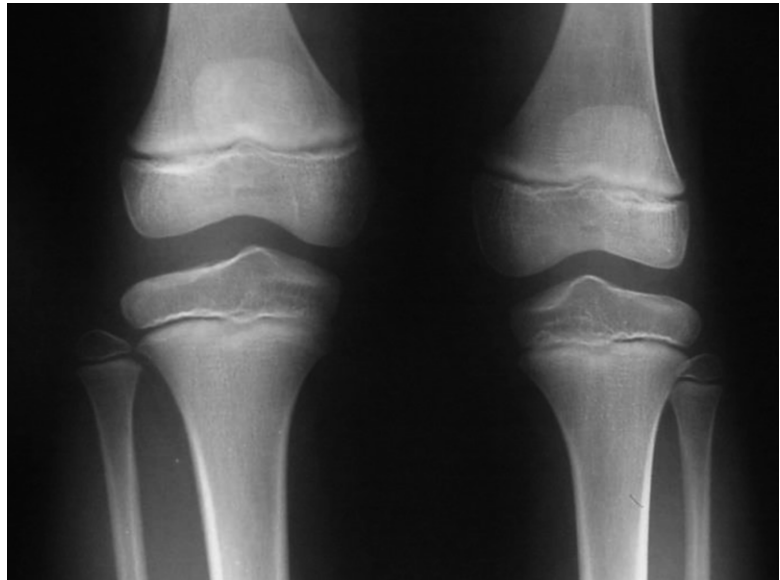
OCD of the medial femoral condyle. The MRI shows that the overlying articular cartilage is intact
